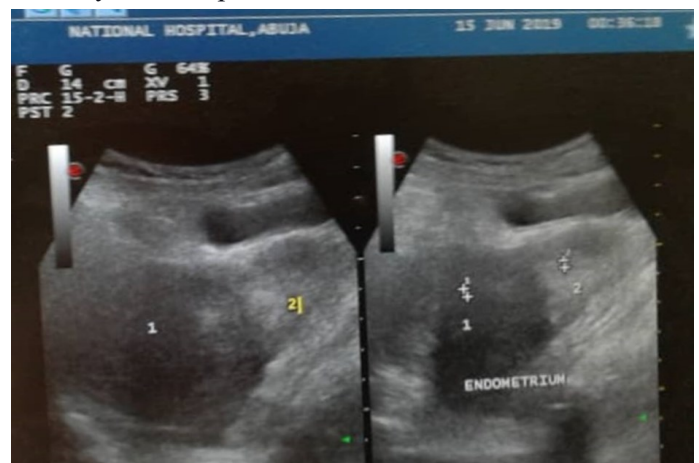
Gray-scale Ultrasound image of the uterus showing a transverse view of two endometrial cavities marked by calipers 1 and 2.
